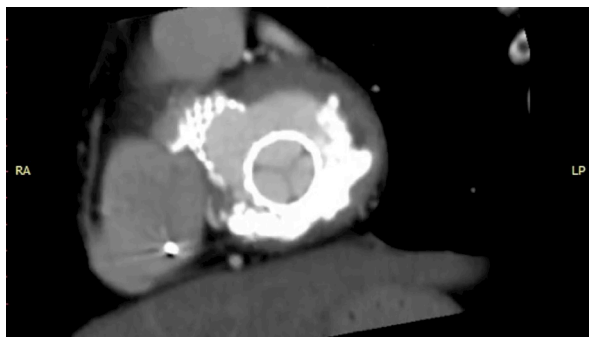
A flow computed tomography angiography scan at the 4-year follow-up shows excellent valve performance, intact leaflet motion, and no subvalvular leaflet thrombosis.
